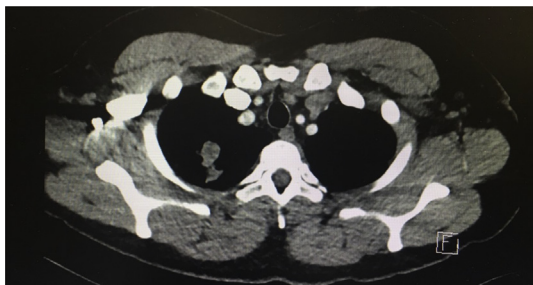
CT scan of the abdomen and pelvis demonstrating a lobulated soft-tissue mass in the right lung apex, likely neoplastic.
